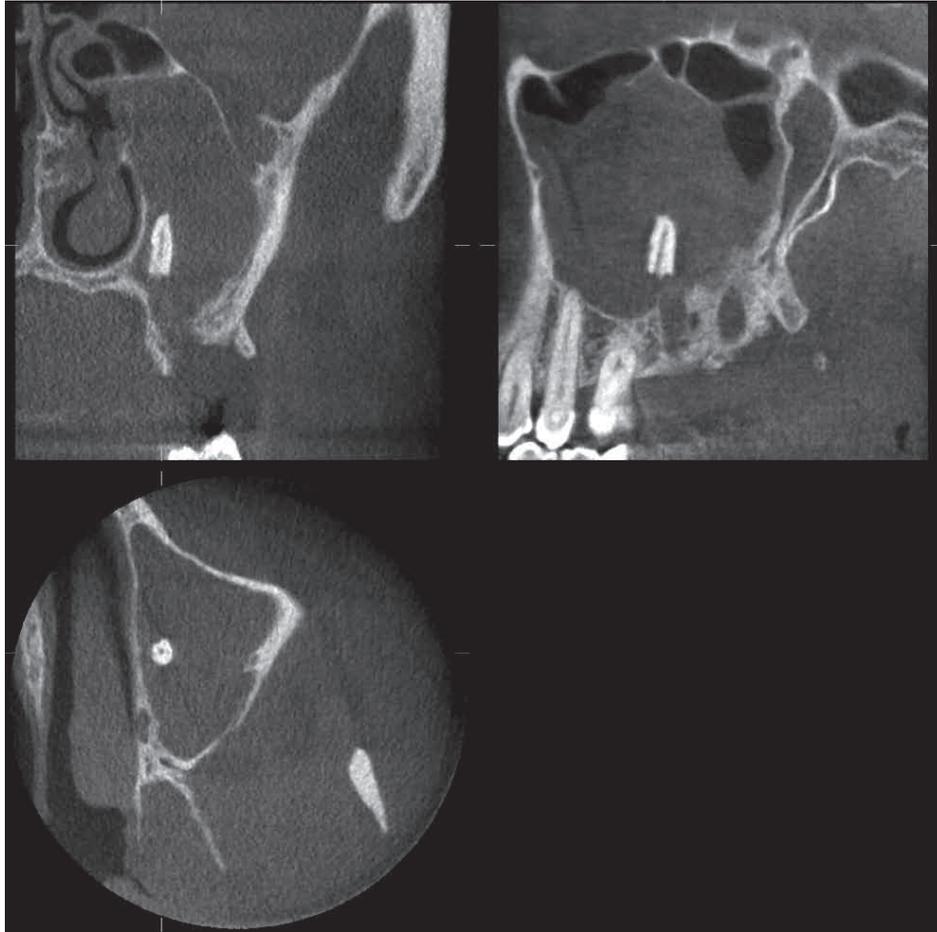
Cone beam CT image.
